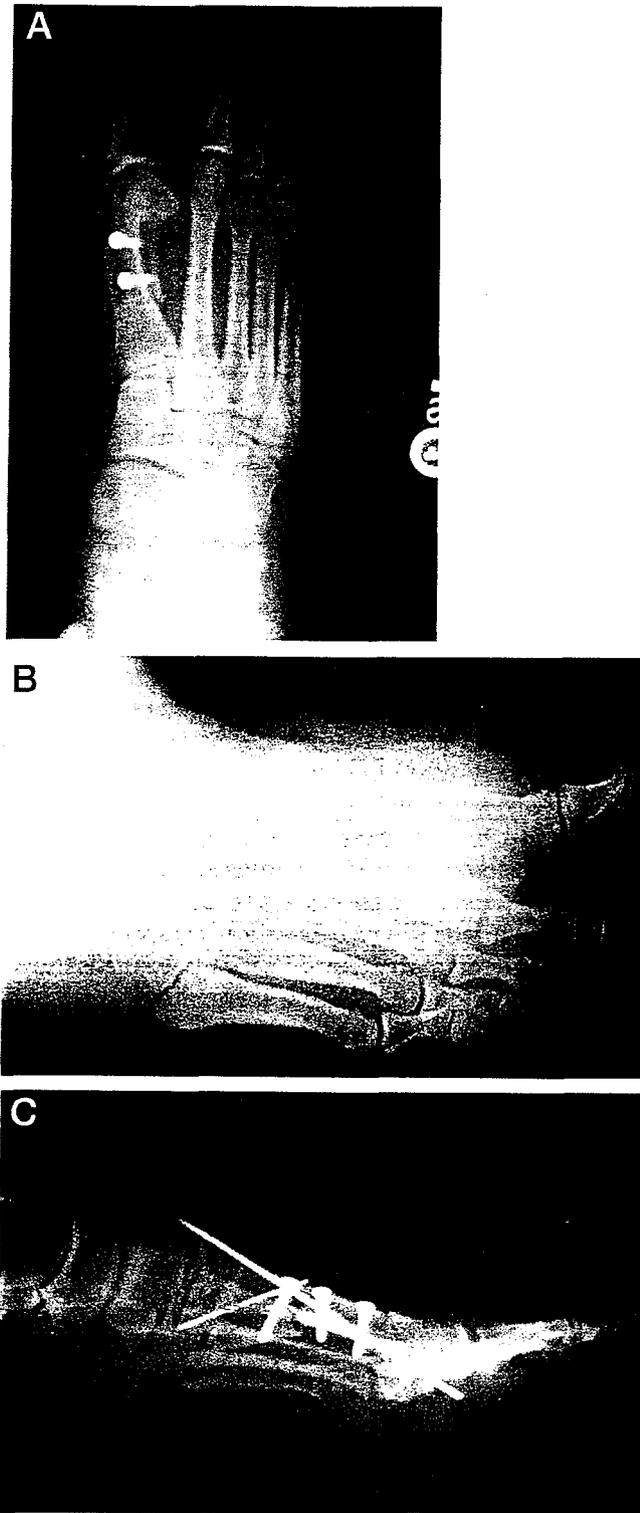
A, Postoperative radiograph of a traditional Z bunionectomy with satisfactory result. B, Oblique radiograph of the same patient showing fracture of the osteotomy 2 days postoperatively after mild trauma to the affected foot. The patient had been walking without surgical shoe protection (unadvised) and subsequently tripped and fell, injuring the surgical area. Fracture locale is at the proximal dorsal aspect
